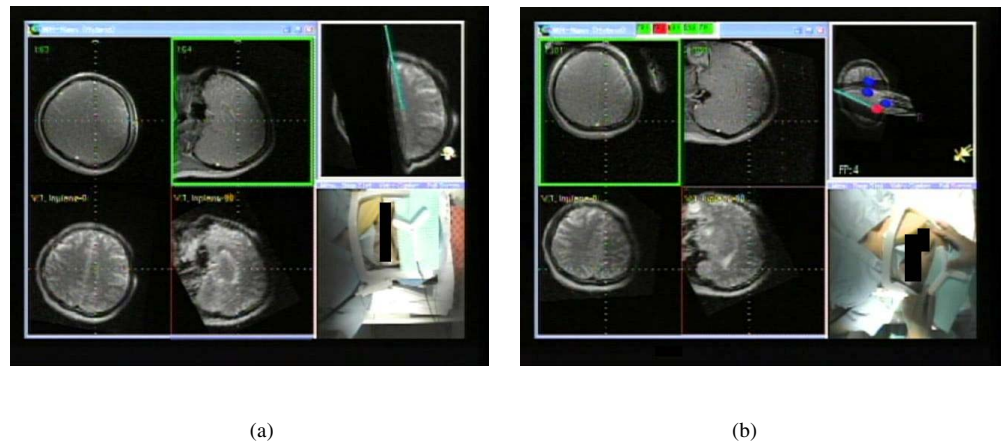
Result of MR image guidance with motion compensation of the patient head movement. (a) Image guidance before movement (b) after head movement
